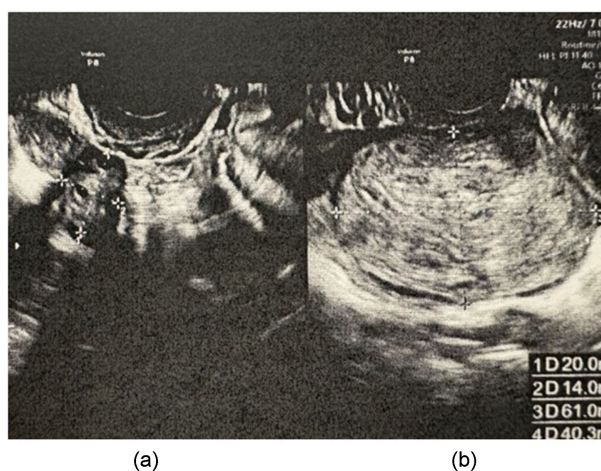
Ultrasound imaging of the (a) right ovary and (b) left ovary. (a) The right ovary is normal. (b) The left ovary shows a 6-cm mass with internal hemorrhage.
